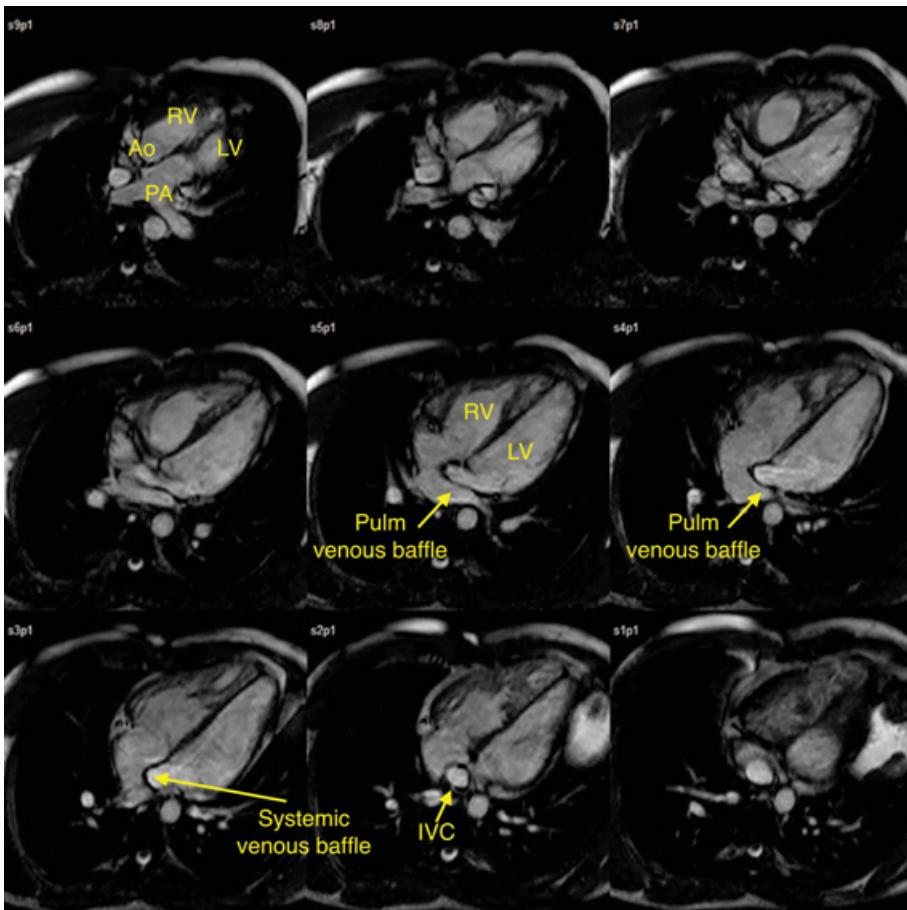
d-Transposition of the great arteries status post atrial baffle (Senning). Panel of four-chamber magnetic resonance imaging showing transposition of the great arteries status post atrial baffle procedure. The pulmonary veins are baffled to the right ventricle and the vena cavae are both baffled to the left ventricle. The resulting circulation is a systemic right ventricle connected to the aorta and a subpulmonary left ventricle connected to the pulmonary artery. Courtesy of Michael Taylor, MD.
